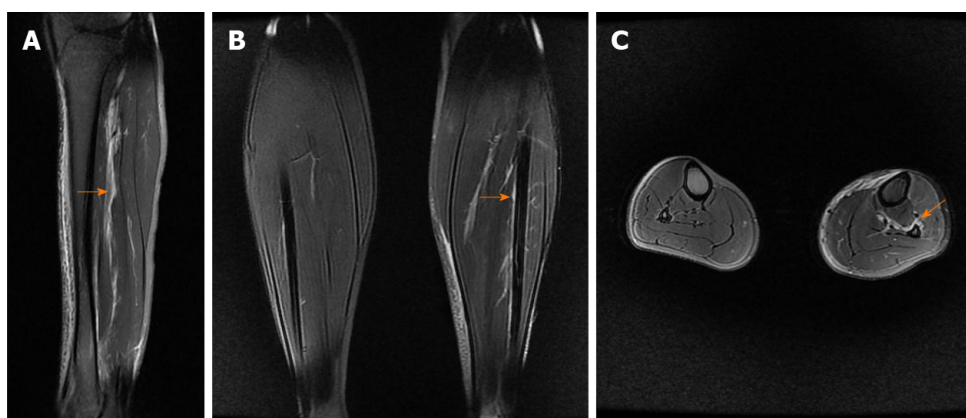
Calf magnetic resonance imaging. A: Sagittal magnetic resonance imaging (MRI) showing high-signal intensity (orange arrow) indicating injury of the interosseous membrane (IOM); B: Coronal MRI showing IOM injury (orange arrow) compared with the contralateral uninjured calf; C: Axial MRI showing IOM rupture (orange arrow) compared with the contralateral uninjured calf, torn from the fibular interosseous crest.
